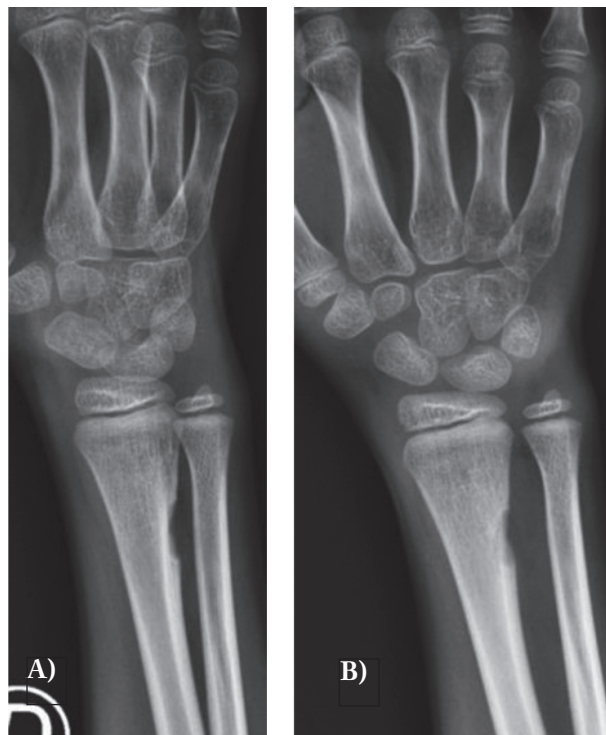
A, B. X-ray performed four months later from a new trauma
